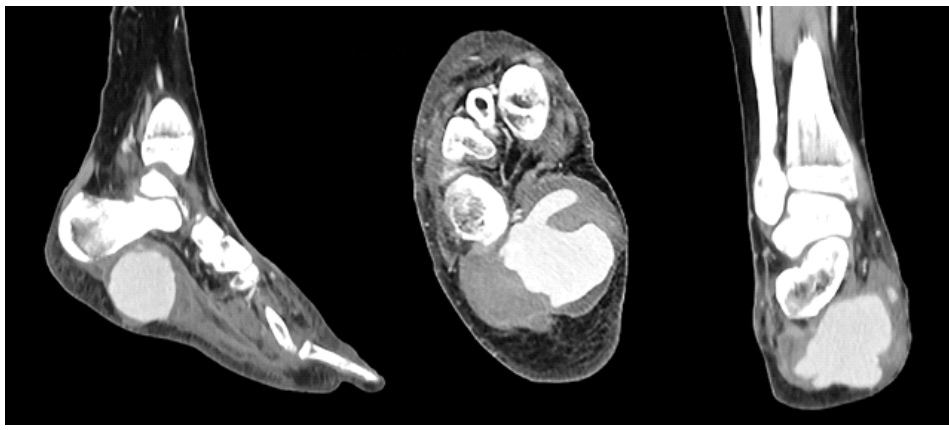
Multiplanar Computed Tomography (CT) reconstruction. Detailed legend – Multiplanar CT reconstruction 36 days after plantar fasciotomy demonstrates a contrast medium blush in the plantar space originating from the lateral plantar artery (9 cm × 6 cm × 7.5 cm).
